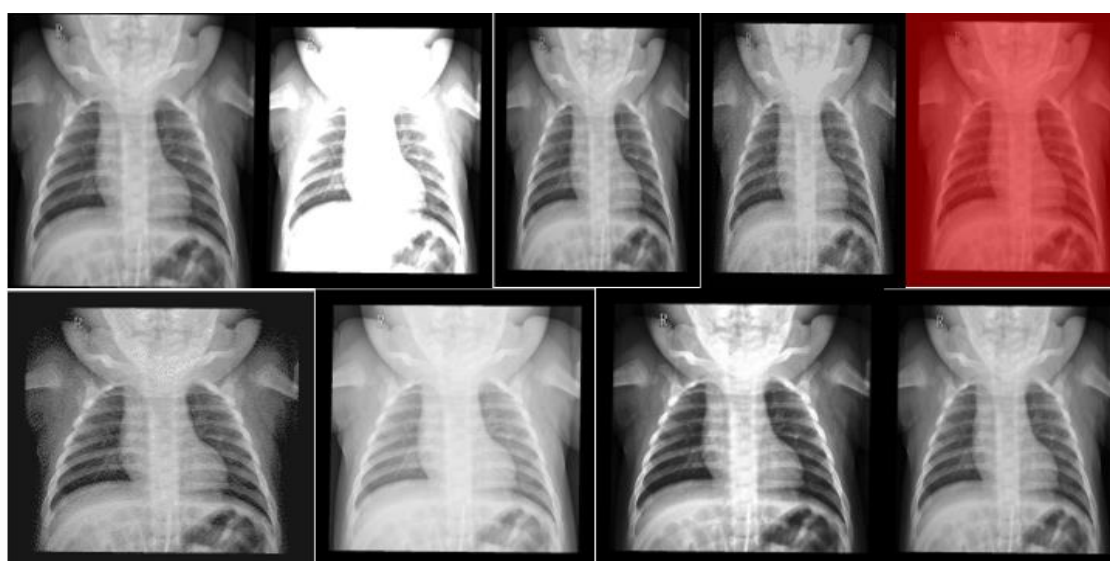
(b): chest radiographic basic colour adjustment; from left, original image, modulated image to brightness of 200, modulated image to saturation of 150, modulated image to hue value of 150, quantized image to maximum value of 10 and colour-space gray, colored image with 50% red, enhanced image, median curve image and equalized image.
